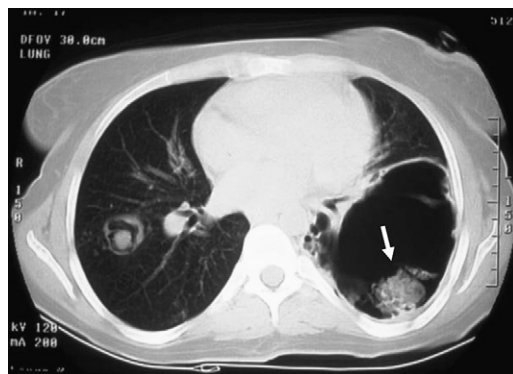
Chest CT of an individual who has *STAT3* deficiency showing the characteristic pneumatoceles. The pneumatoceles are prone to infection with fungi and gram-negative bacteria. Arrow indicates an aspergilloma.
